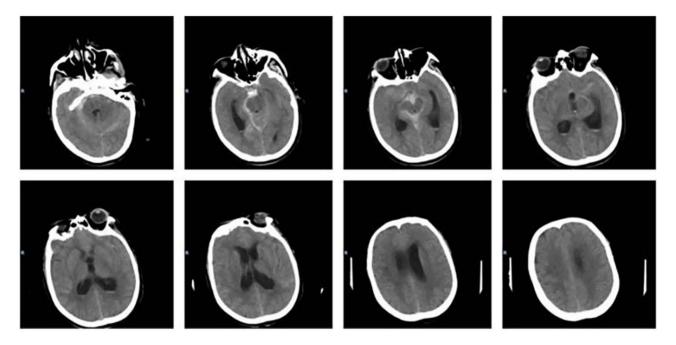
Imaging data of ventricular hemorrhage. CT showed negative SAH around the midbrain, hemorrhage ruptured into the ventricles, and ventricular hematocele.
